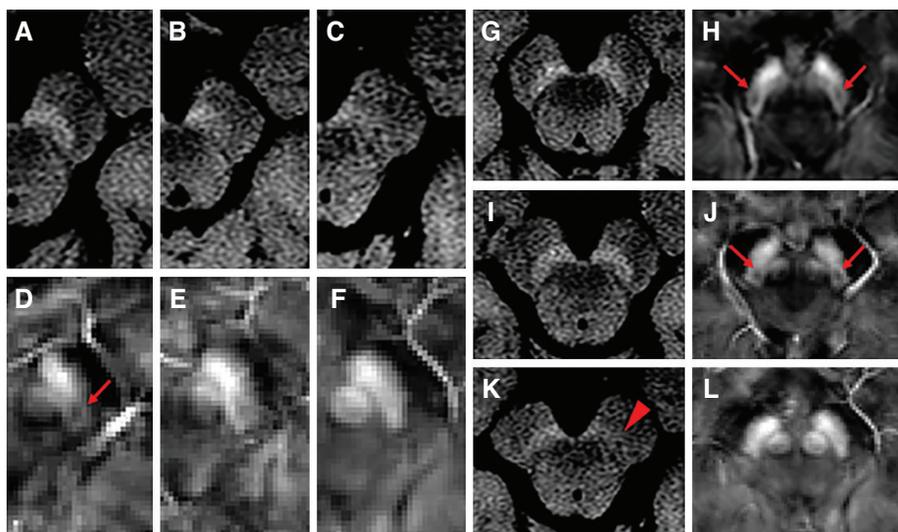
NM-MRI and QSM images. (A-C) represent the normal, possible abnormal and definitely abnormal SN on NM-MRI, respectively. Nigrosome-1 (N1) could be visualized in the dorsal part of the healthy SN on QSM images (D, arrow). D-F represent that N1 was present, indecisively present and absent, respectively. (G-H), a control subject, female 65 years, neuromelanin was normal (G) and N1 was present (H, arrow) in bilateral SN. (I, J), an essential tremor (ET) patient, 59 years, female, neuromelanin was normal (I) and N1 was present (J, arrow) in bilateral SN. (K, L), a de novo PD patient, 75 years female, neuromelanin was definitely abnormal in unilateral SN (K, arrowhead) and N1 was absent in bilateral SN (L). Combined Visualization of Nigrosome-1 and neuromelanin in Substantia Nigra (SN) Using 3T MRI for the Differential Diagnosis of Essential Tremor and de novo Parkinson's Disease. Source: Front Neurol. 2019 Feb 12;10:100. Published with permission.
